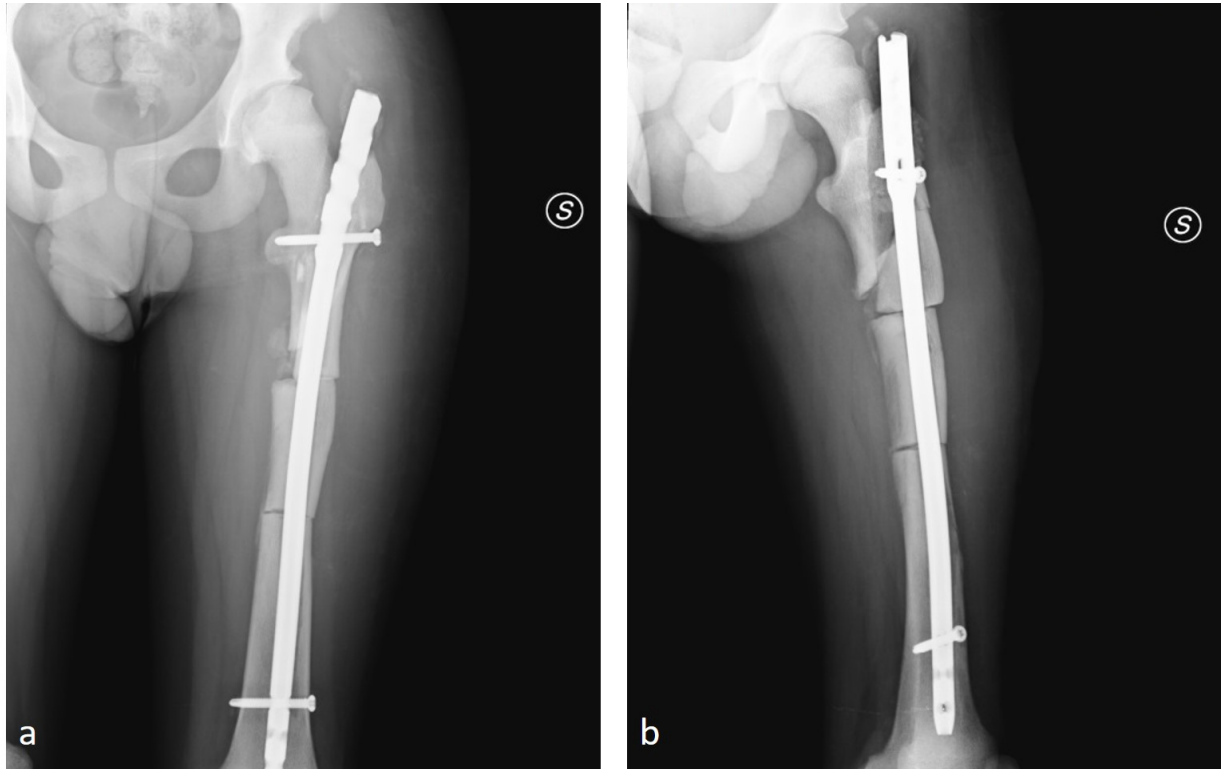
X-rays of the left femur performed at forty postoperative days showing a new per-subtrochanteric fracture and partial proximal migration of the nail: a) anteroposterior view; b) Lateral view
